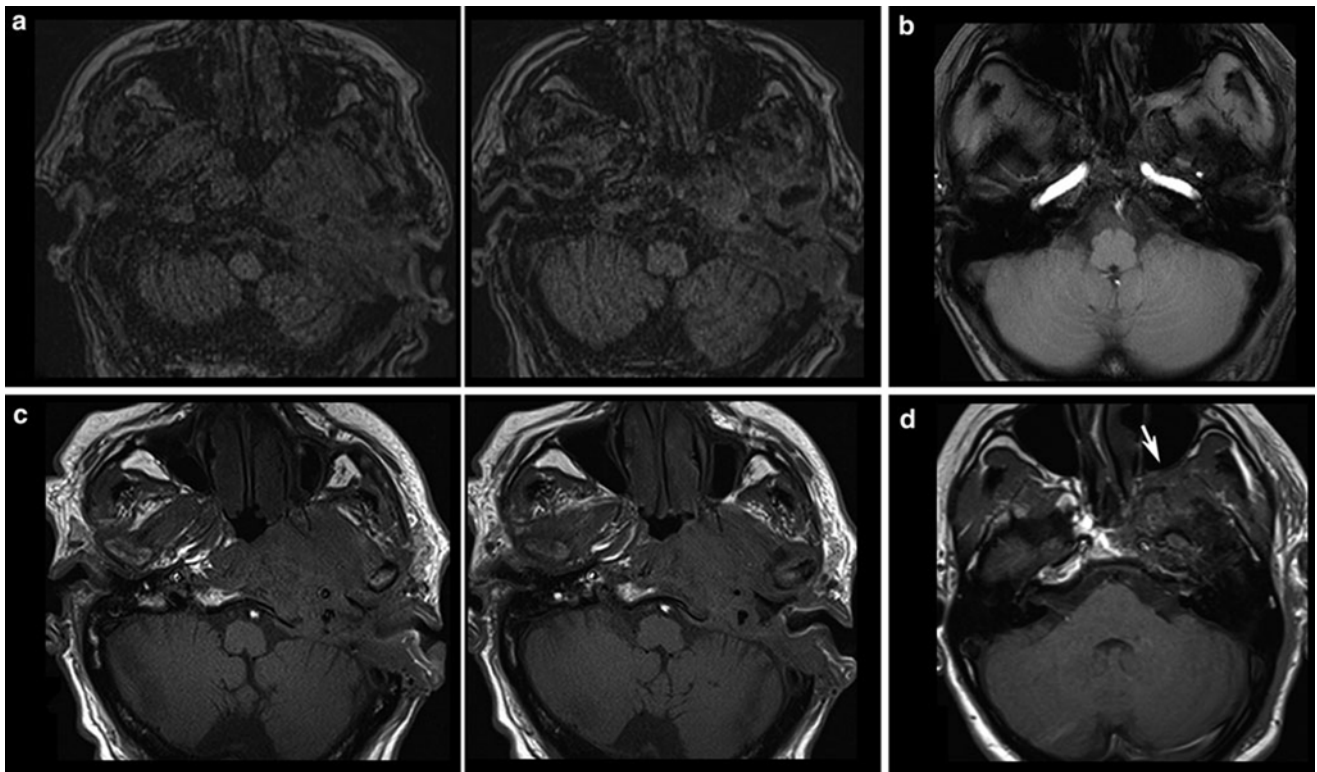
Different T1-weighted sequences without contrast agent at the skull base: In (a) axial slices of a 3D magnetization-prepared rapid gradient echo (MPRAGE) sequence of a patient with malignant otitis externa infiltrating the skull base and in (b) an axial 2D FLASH sequence of a patient with a meningiomas are shown. The corresponding
